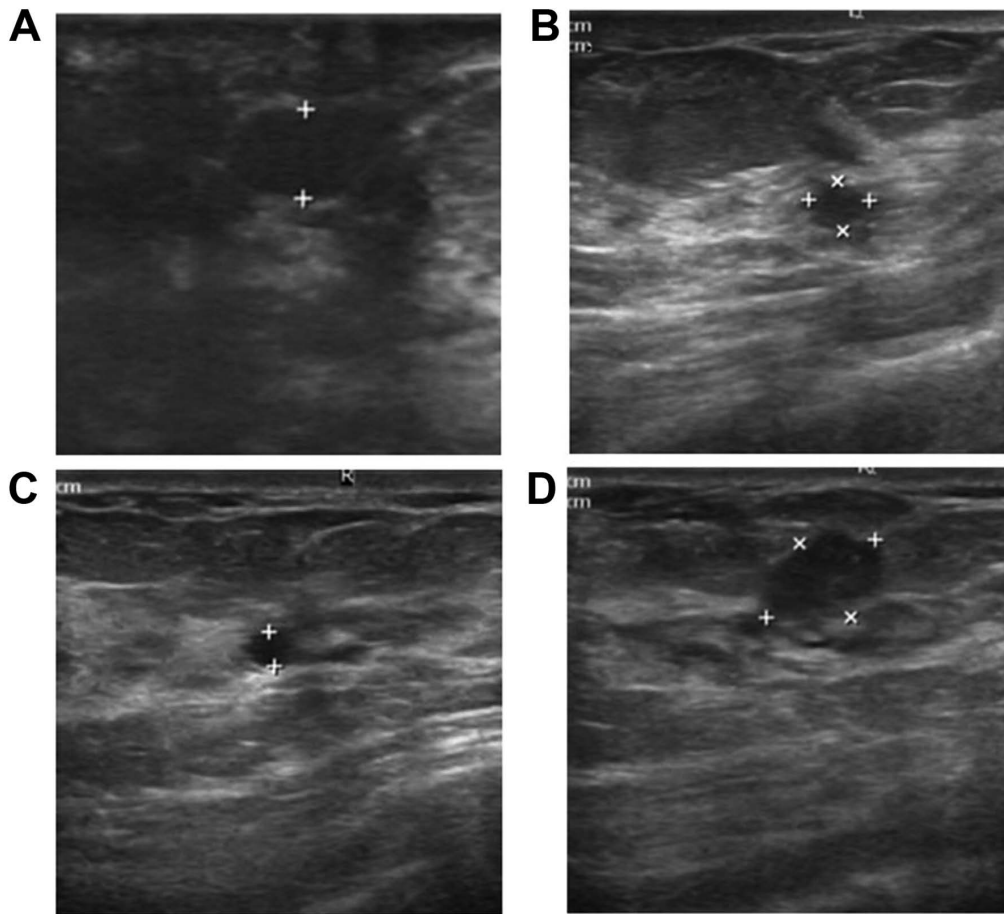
A representative sample of duct ectasia. A 48-year-old woman without PND with breast non-menstrual pain who underwent bilateral breast ultrasonography. Post-operative pathology showed intraductal papilloma in left and right breast. (A) US demonstrates duct ectasia in left breast. (B) US demonstrates a low echoic tumor in left breast, the lesion size is 0.46x0.39 cm. (C) US demonstrates duct ectasia in right breast. (D) US demonstrates a low echoic tumor in right breast, the lesion size is 1.02x0.68 cm.
